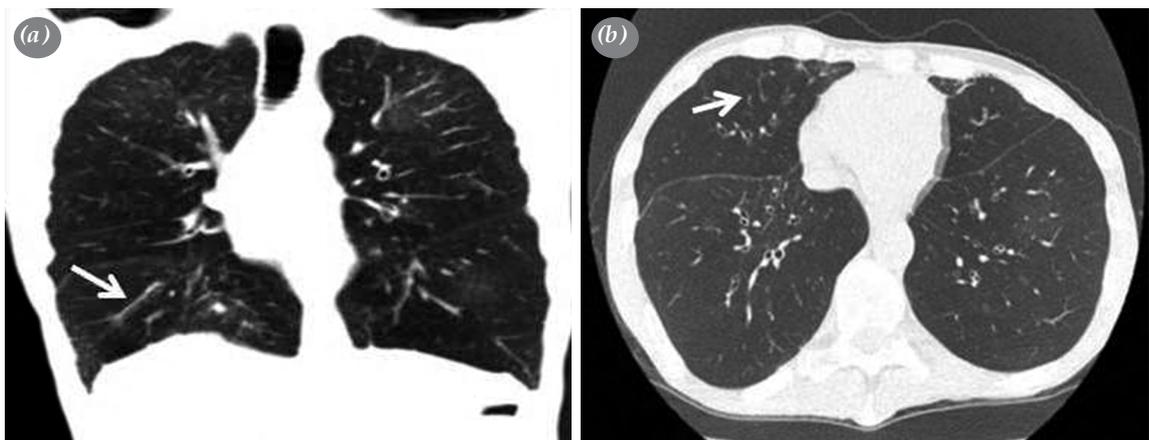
(a) Bilateral diffuse bronchiectasis areas (white arrow) and (b) ground-glass views on coronal reformatted axial images of thoracic computed tomography (white arrow).
